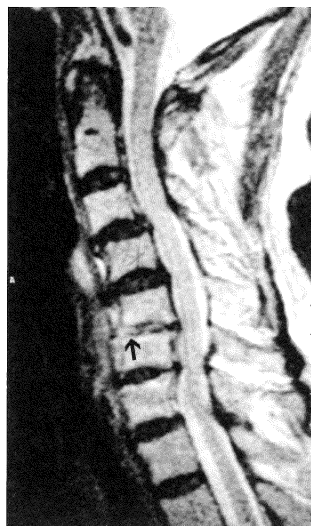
MRI cervical spine (sagittal view) on 10-11-1996: the intervertebral disc over C5/6 level (arrow) shows hyperintense signal on T2 weighted image compatible with discitis.
